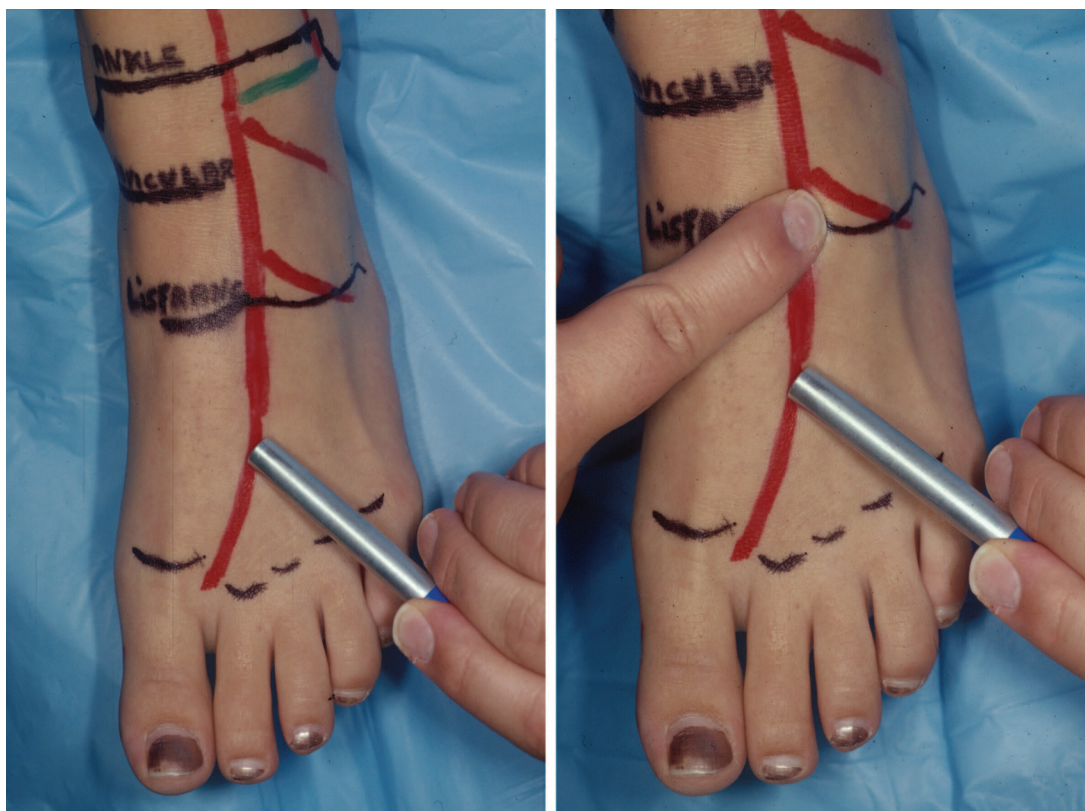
The antegrade and retrograde flow of the first dorsal metatarsal artery is being evaluated. (Left) The Doppler device is placed over the artery. (Right) The dorsalis pedis is then occluded at the proximal first interspace. If there still is a signal, then there is retrograde flow from the first web space.
